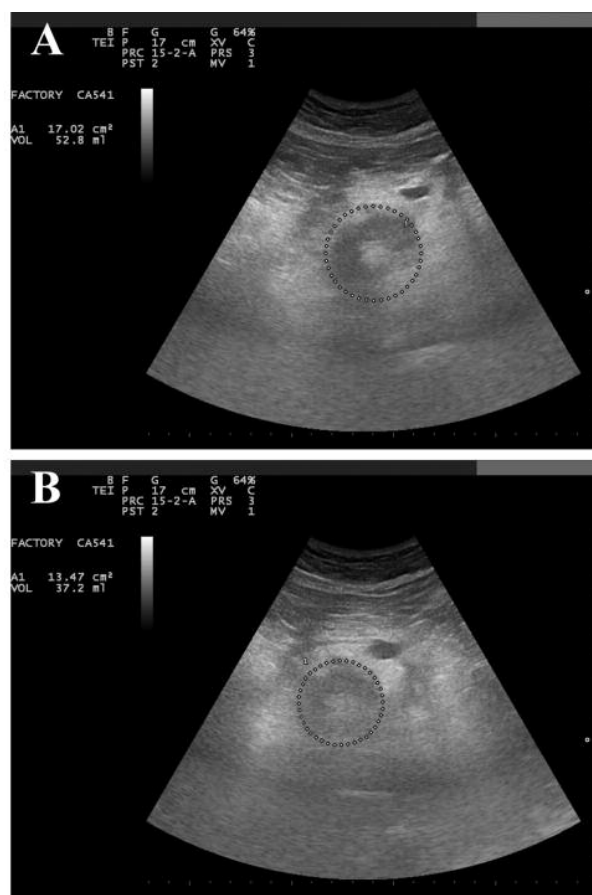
Ultrasonography of a peritoneal lesion associated with metastatic adenocarcinoma of the pancreas before and after OA-GcMAF-based immunotherapy. These images refer to clinical case #2 and were taken before treatment (panel A), and after two weeks (panel B).
